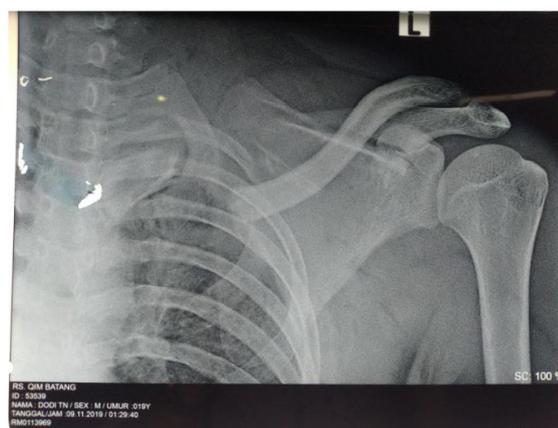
X-ray of chest and left shoulder of the patient after an accident. Discontinuity of 1/3 medial left clavicle bone, alignment was not good; Discontinuity of superior margo of left scapula; Both indicated fracture of 1/3 medial left clavicle and superior margo of left scapula.
